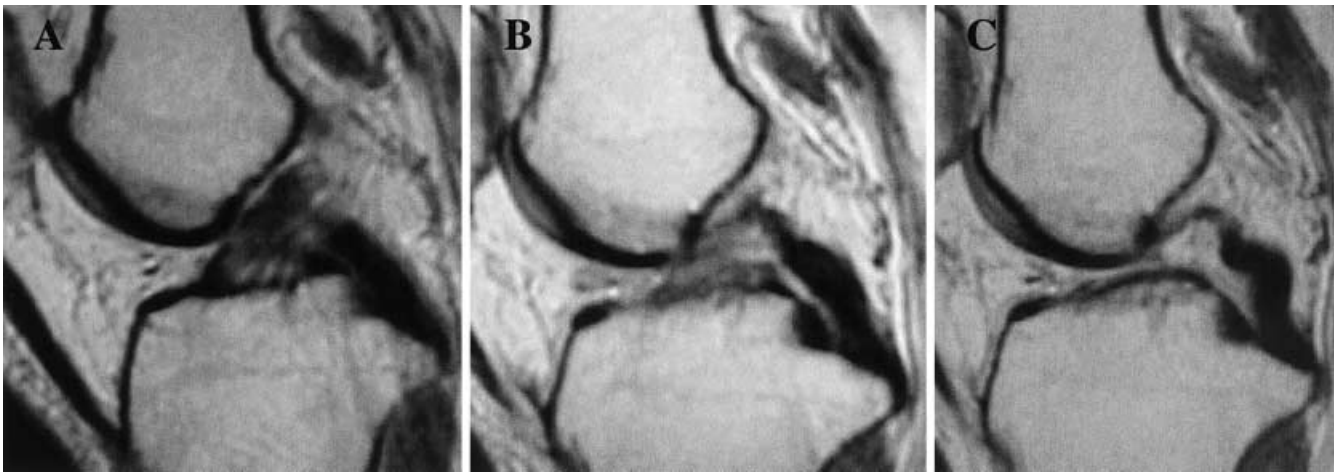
MRI taken 26 days after injury shows high signal intensity in the substance of the ACL (A). After 3 months of bracing, the injured ACL became unclear (B). The injured ACL has disappeared, and a sigmoid PCL is seen at 12 months after the injury (C)
